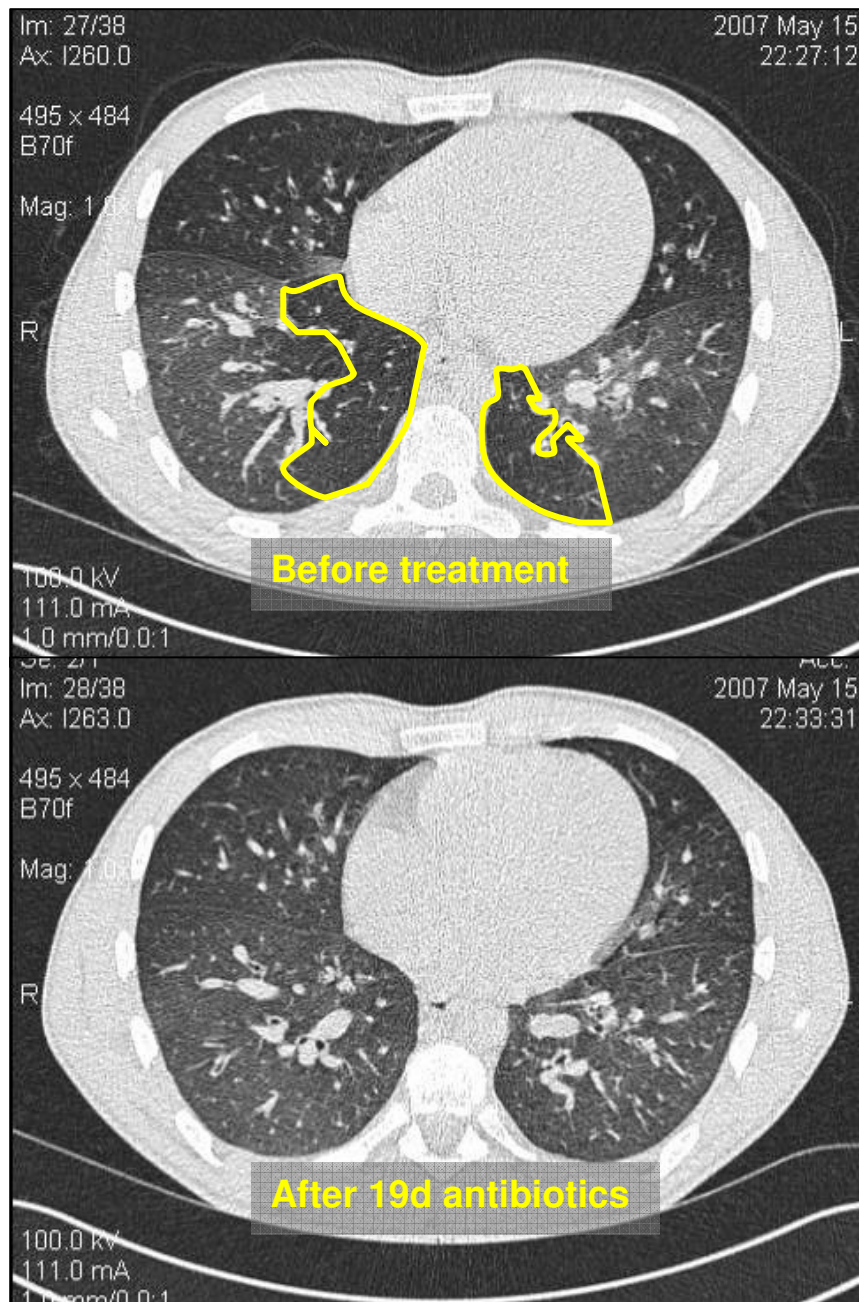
Large mucus plugs seen on HRCT in a bronchus in the left lower lobe (circled) of an 18 year old female with CF at the start of an exacerbation (top) and after 19 days of intravenous antibiotics. Following treatment, the airway has been largely cleared of the obstructing mucus. For this subject, overall mucus plug score improved from 20 to 11.
